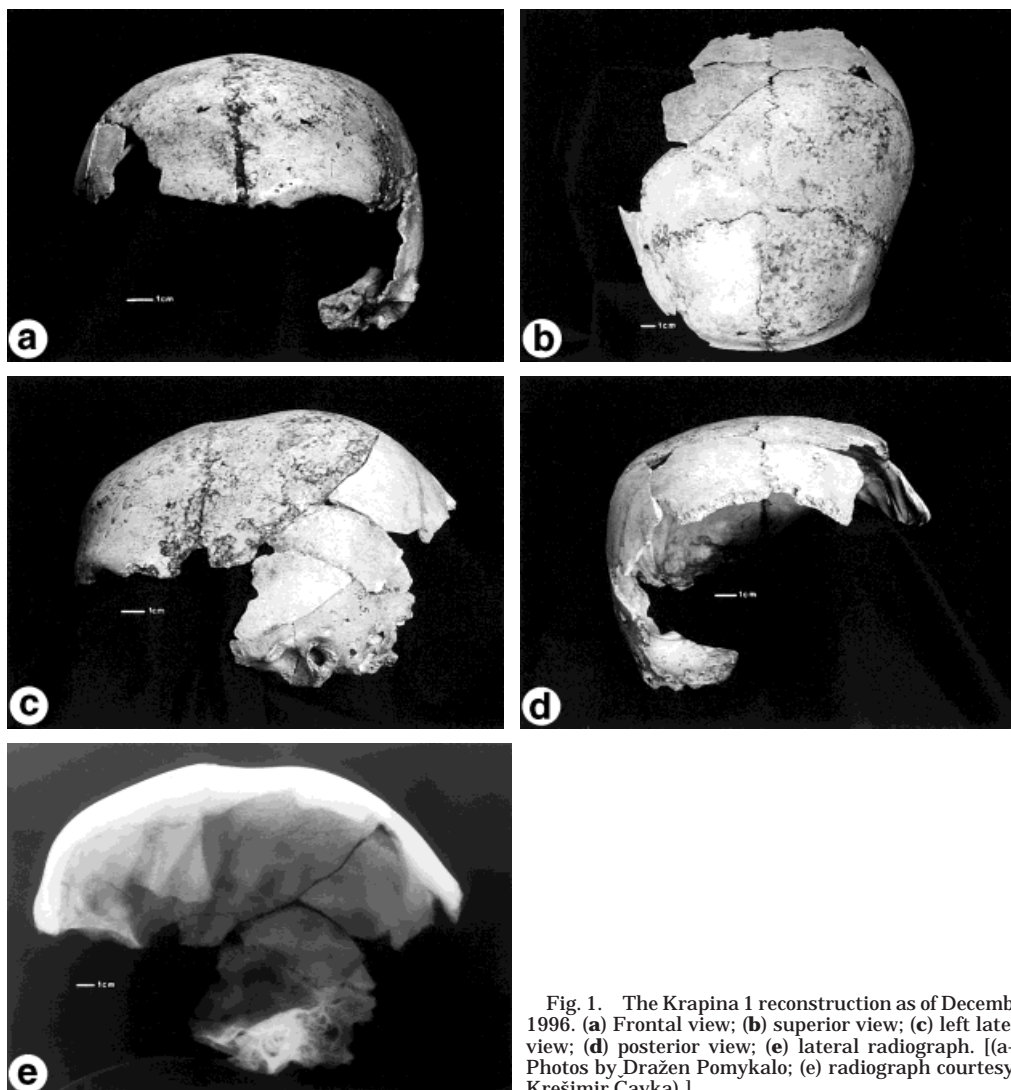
The Krapina 1 reconstruction as of December, 1996. (a) Frontal view; (b) superior view; (c) left lateral view; (d) posterior view; (e) lateral radiograph. [(a–d) Photos by Dražen Pomykalo; (e) radiograph courtesy of Krešimir Čavka].
